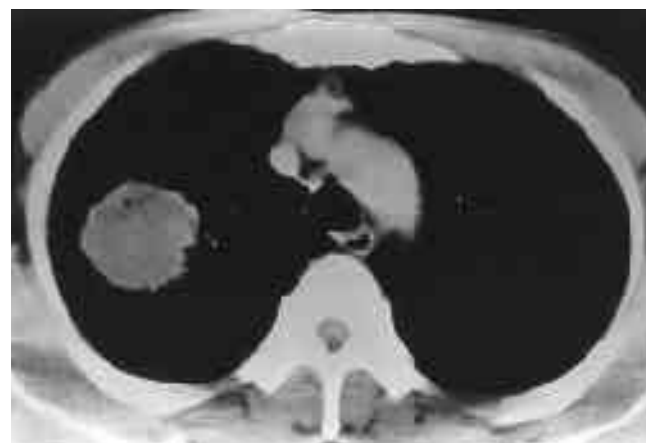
Mixed small cell-large cell carcinoma in a 55-year-old male patient. Post-contrast CT scan at the level of the aortic arch shows a 4.5×4.5 cm-sized, round, inhomogeneous mass with focal air density.
